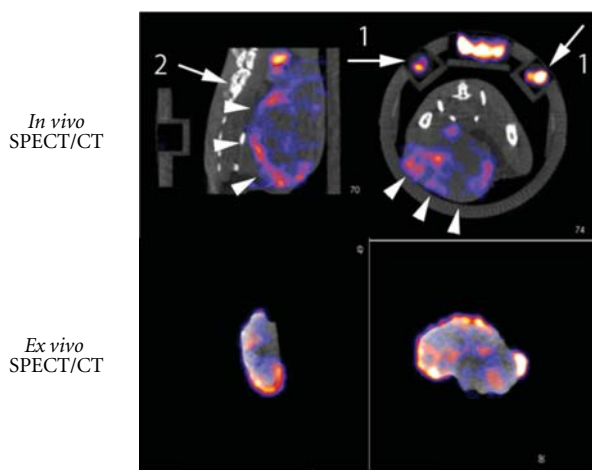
In vivo* visualization of heterogeneous intratumoral distribution of POS by SPECT/CT. The comparison of *in vivo* SPECT images and *ex vivo* images. Upper row: *in vivo* SPECT images, lower row: *ex vivo* SPECT images, left column: sagittal sectional images, right column: axial sectional images. Arrows 1: markers for coregistration, arrows 2: vertebrae, and arrowheads: the tumor.
